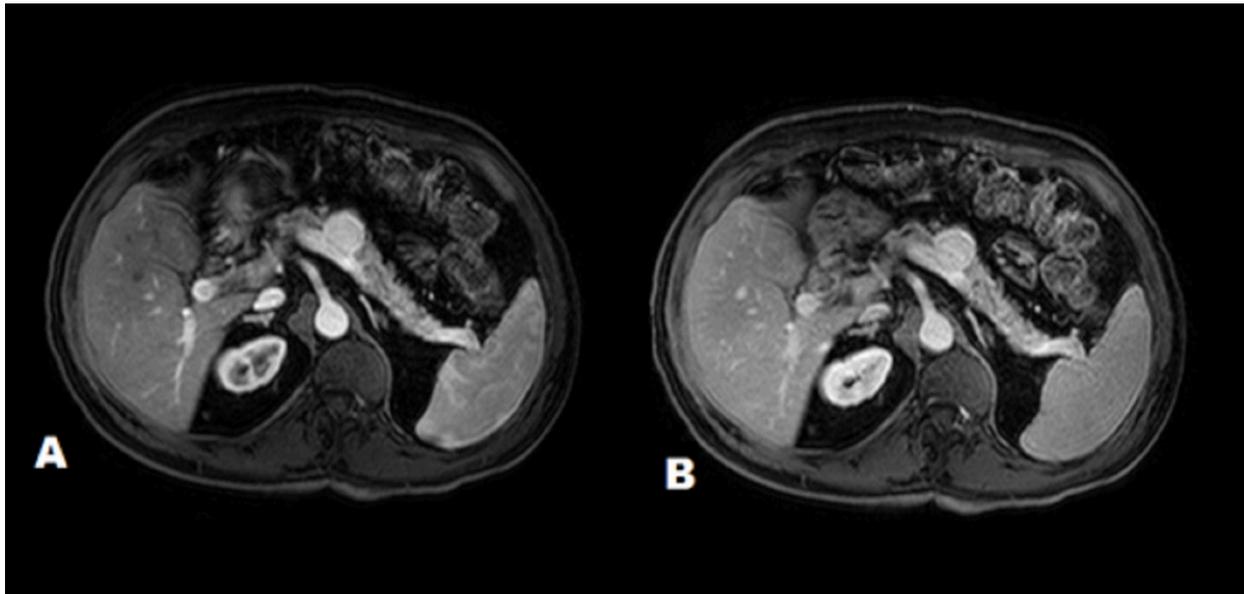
Magnetic resonance imaging showed a nodular area adjacent to the pancreatic body, in contact with the splenic vein, presenting with portal enhancement. References: Radiology Department, São Carlos Imagem, São Carlos Hospital - Fortaleza/BR 2018
